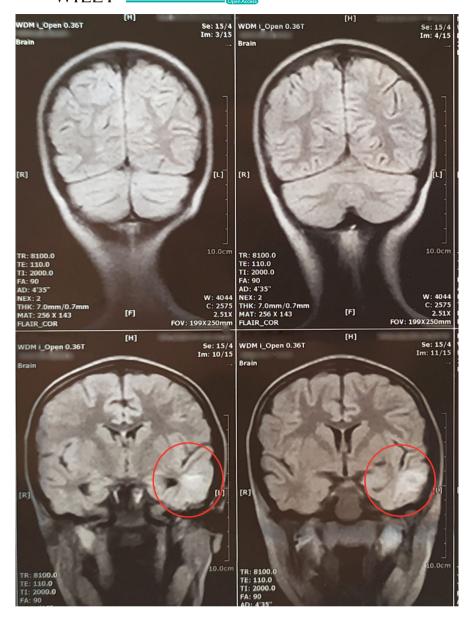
Coronal MRI T2-Flair image shows 1.7 mm mass (circle)
